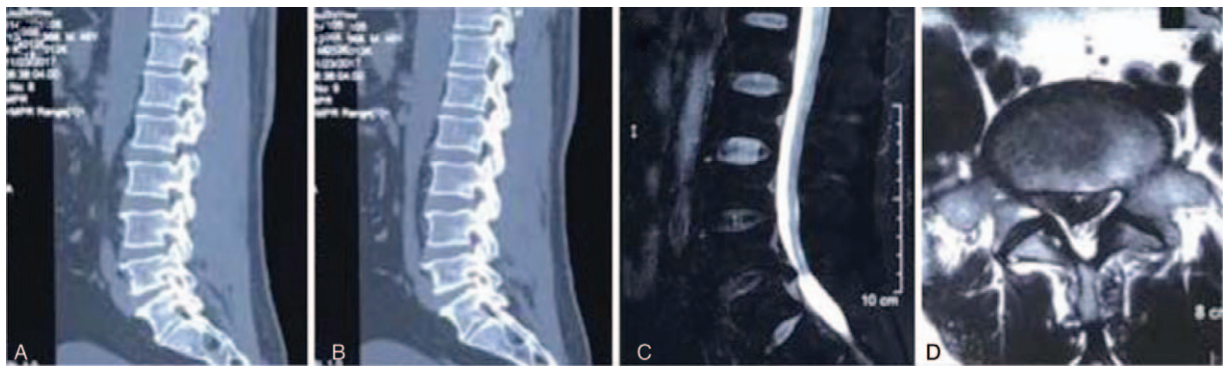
Preoperative sagittal CT showing that the left foramen is narrow and collapsed caused by hyperplastic SAP of S1 (A and B). Preoperative MRI shows the compressed dural sac due to L5-S1 disc herniation (C) and central type LDH (D). CT = computed tomography, LDH = lumbar disc herniation, MRI = magnetic resonance imaging.
